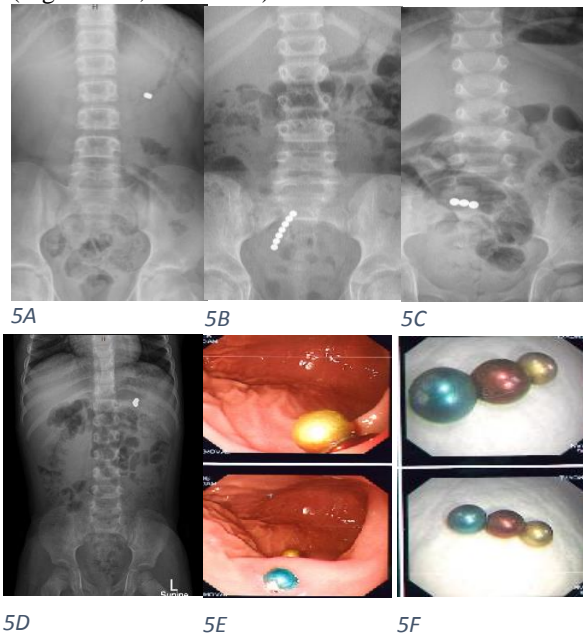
5B, 5C, 5D, 5E and 5F: Abdominal x-rays showing five patients with different swallowed magnets with and without intestinal obstruction.
